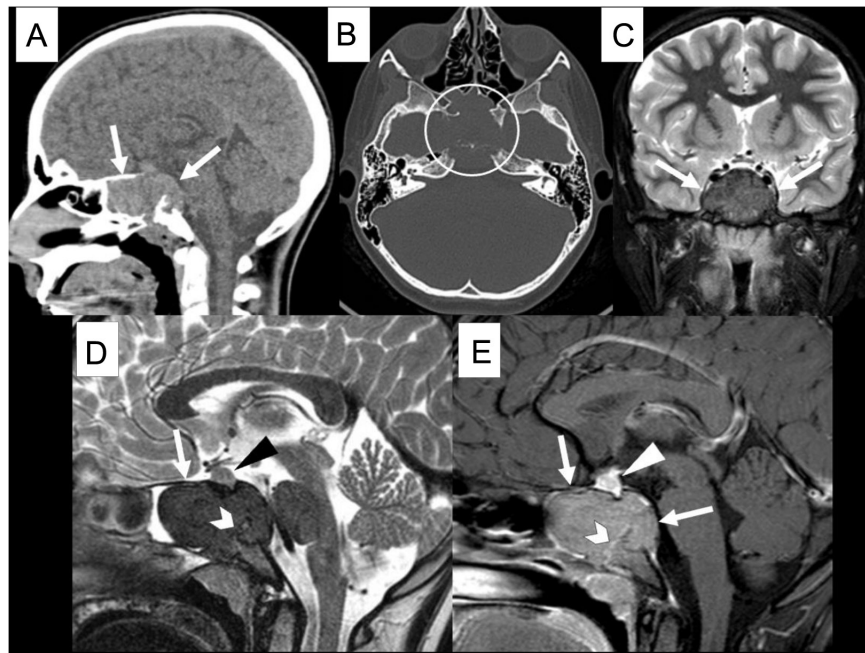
(a) Sagittal soft-tissue window and (b) axial bone window CT scans show a large mass centered in the sphenoid bone, with resorption of the dorsum sellae and posterior sphenoid wall (arrows, a). Notice the extensive bone resorption in the central skull base (circle, b). (c) Coronal T2 short-tau inversion recovery, (d) sagittal T2-weighted image, and (e) contrast-enhanced sagittal T1-weighted images confirm the presence of a large central skull base mass (arrows, d, e), which abuts the posterior fossa posteriorly. Despite its large size, the mass respects the sphenoid-occipital synchondrosis (arrowheads, d, e) and restricts the pituitary fossa, with elevation of the pituitary gland (triangle, d, e).
